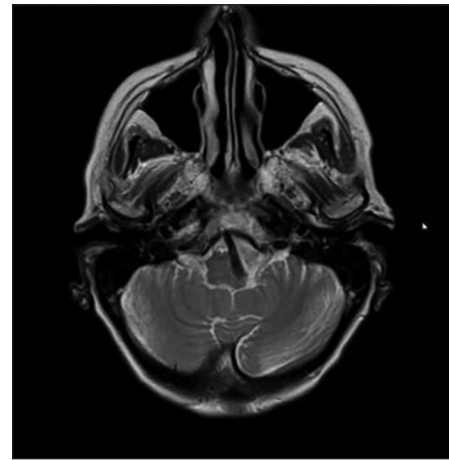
Preoperative magnetic resonance imaging (MRI) T2 sequences showing compression of the medulla by the vertebral artery
